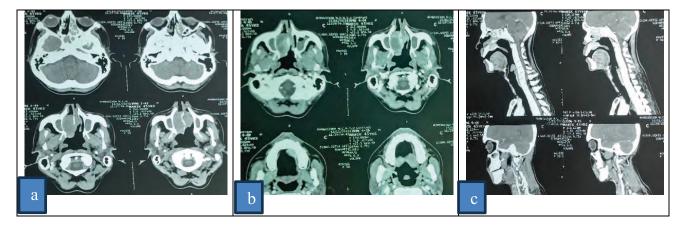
Non-contrast axial CT scan of nose and paranasal sinuses shows soft tissue mass involving both nasal cavity (more in right) with irregular destruction of nasal bone (a). Contrast enhanced axial (b) and sagittal (c) CT scan of nose and paranasal sinuses show heterogeneous contract enhancing soft tissue mass involving both nasal cavity (more in right) with irregular areas of nasal bone and palatine bone destruction.
